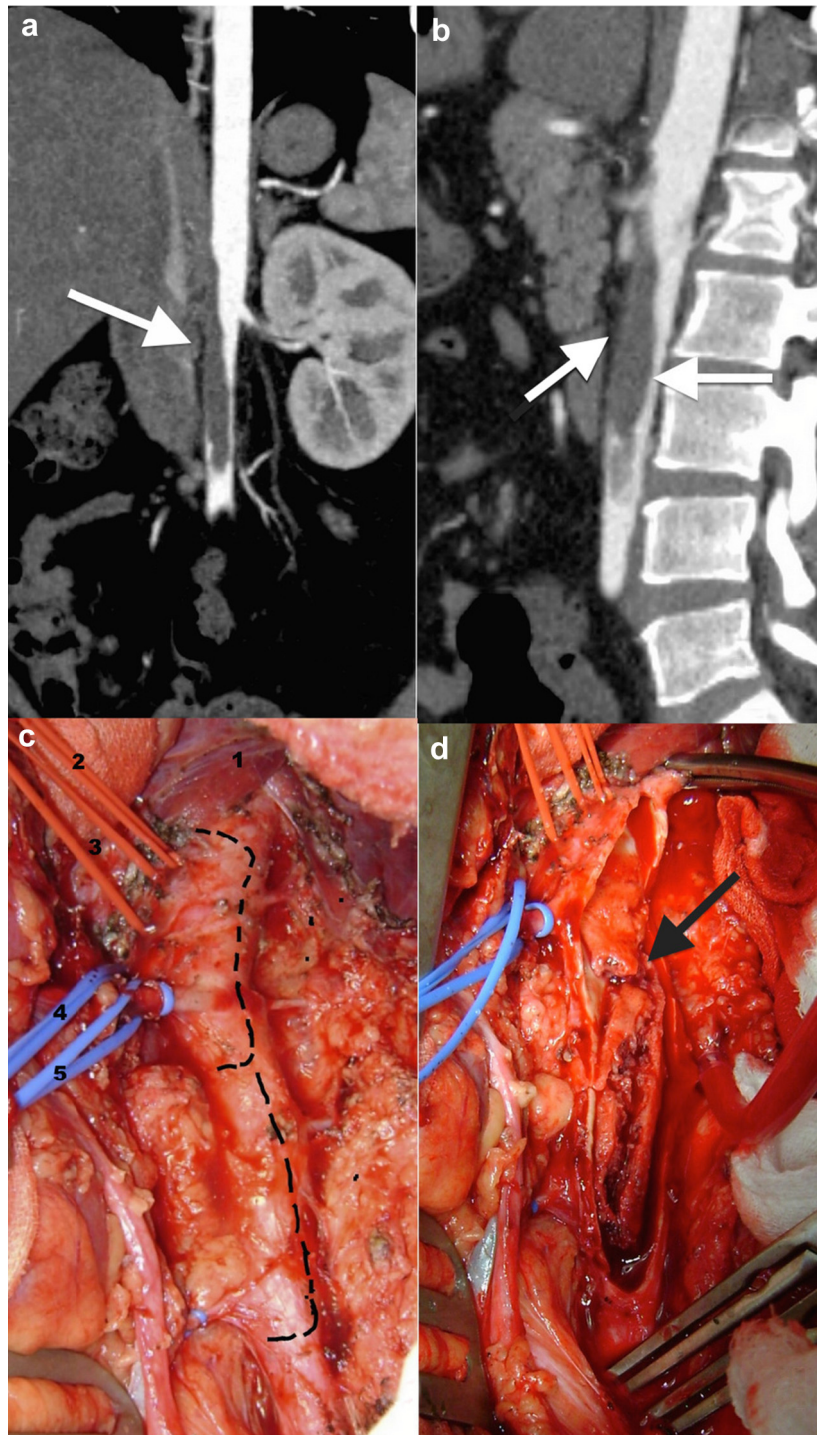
Trapdoor thrombectomy for type III primary aortic mural thrombus (PAMT). a and b, Preoperative computed tomography (CT) scan showing type III PAMT (*arrow*) in coronal and sagittal sections. c, Medial visceral rotation and supraceliac aortic dissection until diaphragmatic crus (*1*). Silastic loop control of celiac trunk (*2*), superior mesenteric artery (*3*), and right (*4*) and left (*5*) renal arteries. Incision line for trapdoor aortotomy (*dotted line*) could extend inferiorly if thrombus extends below in infrarenal aorta. d, Intraluminal thrombus is seen after trapdoor aortotomy (*arrow*). Aortic thrombectomy and embolectomy from individual visceral vessel could be performed.
